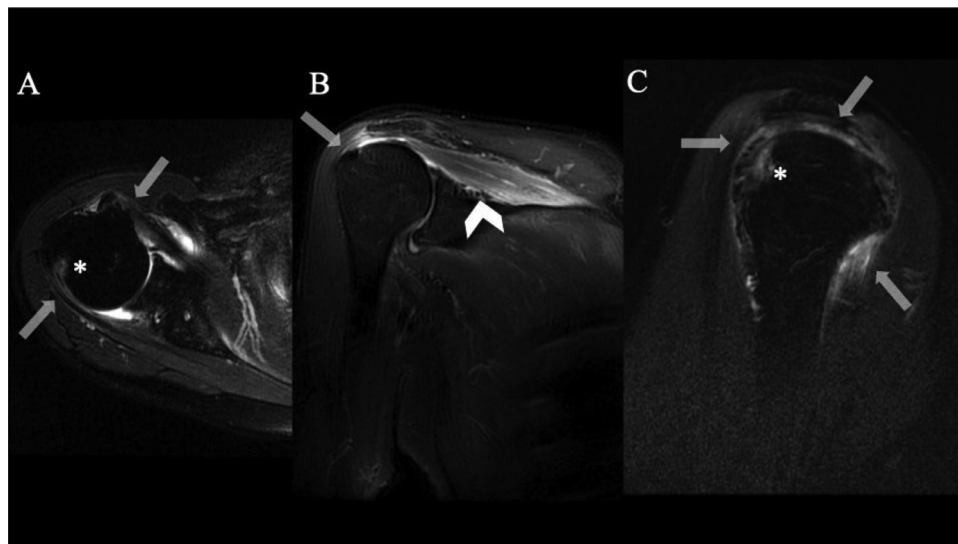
(A) Axial short tau inversion recovery (STIR) magnetic resonance imaging (MRI) of the right shoulder showed a high signal at the entheses of the infraspinatus and subscapularis (arrow). Bone marrow oedema was found in the greater tuberosity of the humerus (asterisk). (B) The supraspinatus muscle had a high signal on coronal STIR MRI (arrowheads), with enthesitis of the supraspinatus (arrow). (C) Sagittal STIR MRI revealed enthesitis of the supraspinatus, infraspinatus and subscapularis (arrow). Bone marrow oedema was observed in the greater tuberosity of the humerus (asterisk).
